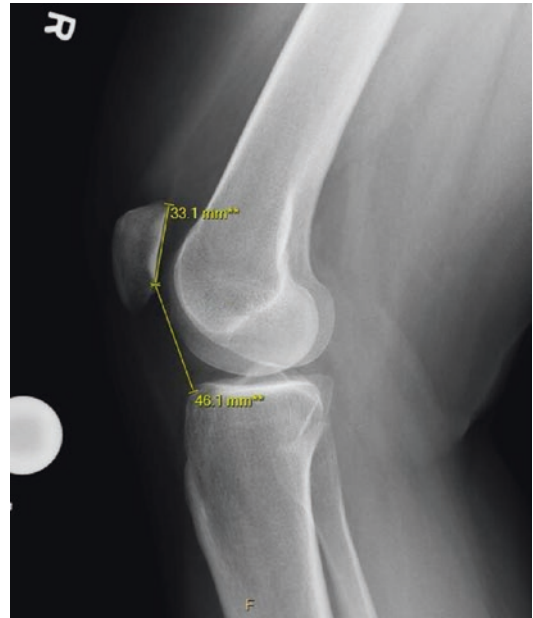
Lateral radiograph of the right knee demonstrating elevated Caton–Deschamps ratio
